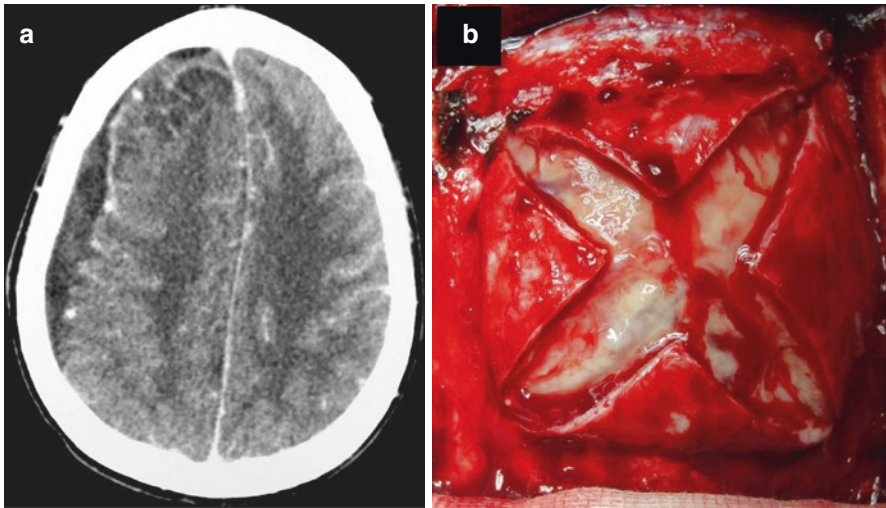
Axial cranial post-contrast CT-scan showing frontal subdural empyema on the right side (a). Operative view of the frontal subdural empyema following dural opening (b)
